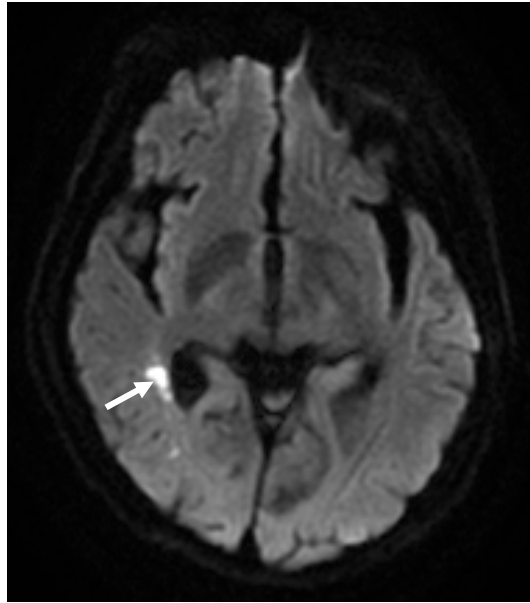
Scan from diffusion-weighted imaging (DWI) showing acute embolic infarcts (white arrow) of the right middle cerebral artery territory associated with carotid atherosclerosis. This image is from a 51-year-old male with left carotid atherosclerosis, who had experienced dizziness and headache for one week. (From Zhongshan Hospital of Fudan University, Shanghai, China)
